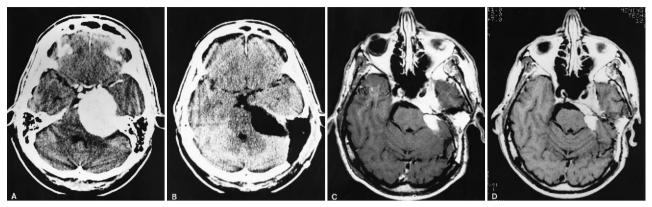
Case 1. Computerized tomography (CT) and magnetic resonance (MR) images showing associated cavernous sinus involvement. A 72-year-old man presented with a 3-year history of progressive gait ataxia, right leg paresis, and left-sided hearing loss. There was no evidence of clinical oculomotor paralysis or facial sensory loss. Note the large left petroclival tumor with obvious cavernous sinus involvement (A). Following a combined supra- and infratentorial petrosal approach, the tumor was resected from the posterior fossa, although the portion of the tumor entering Meckel's cave was not removed. Postoperative CT (B) shows resection of the posterior fossa component with a fat graft placed in the temporal bone defect. Three-month postoperative MR images show residual tumor in the cavernous sinus (C) which remains unchanged over a 3-year follow-up period (D). Note the high-intensity fat graft remaining at the position of the apex of the petrous bone. The patient has demonstrated no clinical progression, with binocular vision.
